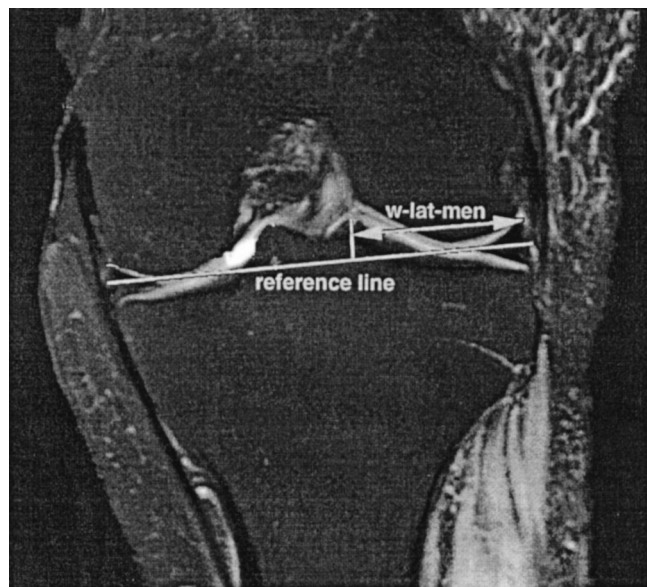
Example MR image in the sagittal plane indicating one of the four transverse dimensions measured. The depth of the lateral meniscus was measured from the sagittal image that best bisected the lateral compartment. A reference line was drawn through the tibial plateau and the depth of the lateral meniscus was measured parallel to that line.
